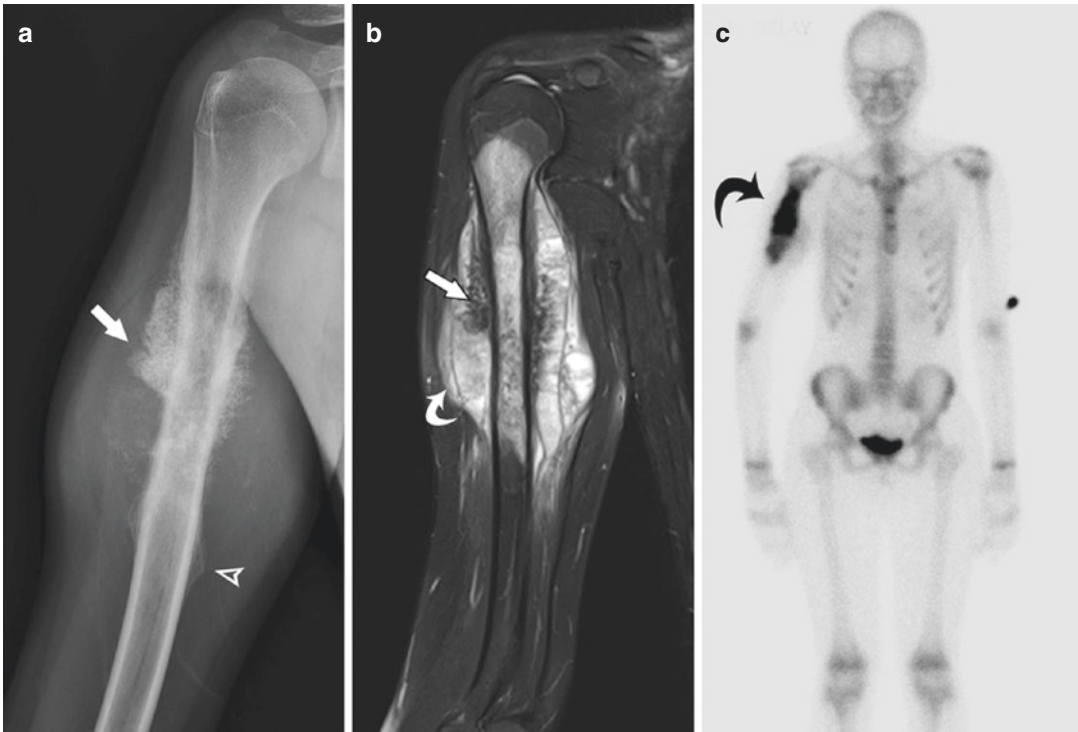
Osteosarcoma: 15-year-old female with right upper extremity mass. Radiograph (a) reveals a mixed pattern of sclerosis and lucent areas. Aggressive periosteal reaction is present within the soft-tissue component (arrow). Codman triangles are present distally (arrow-head). (b) Coronal T2-weighted (TR2700, TE76) sequence with fat saturation of the entire humerus is performed to look for skip metastases (not present in this
